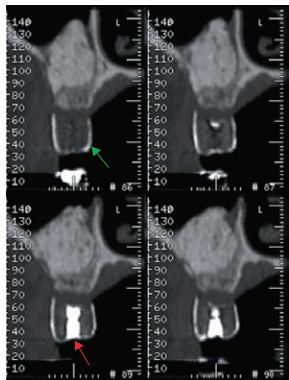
Radiographic template: titanium guide sleeves allow visualization of implant direction and indicate surgical placement.
